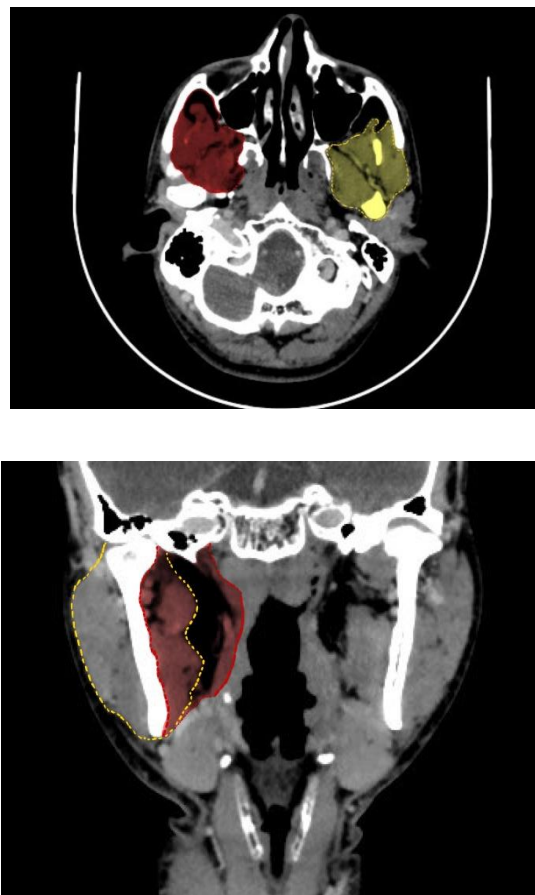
Axial and Coronal Section of CT Scan Showing Extent of ITF (red line and shadow) and Differentiating it from Masticator space (yellow lines).
